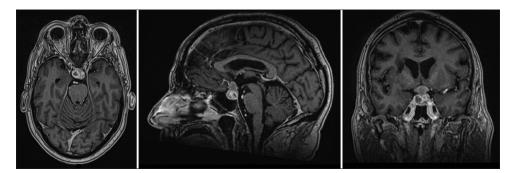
Postcontrast magnetic resonance imaging Head (Axial, Sagittal and Coronal Views) demonstrating the heterogeneously enhancing pituitary lesion with suprasellar extension compressing the optic chiasm
